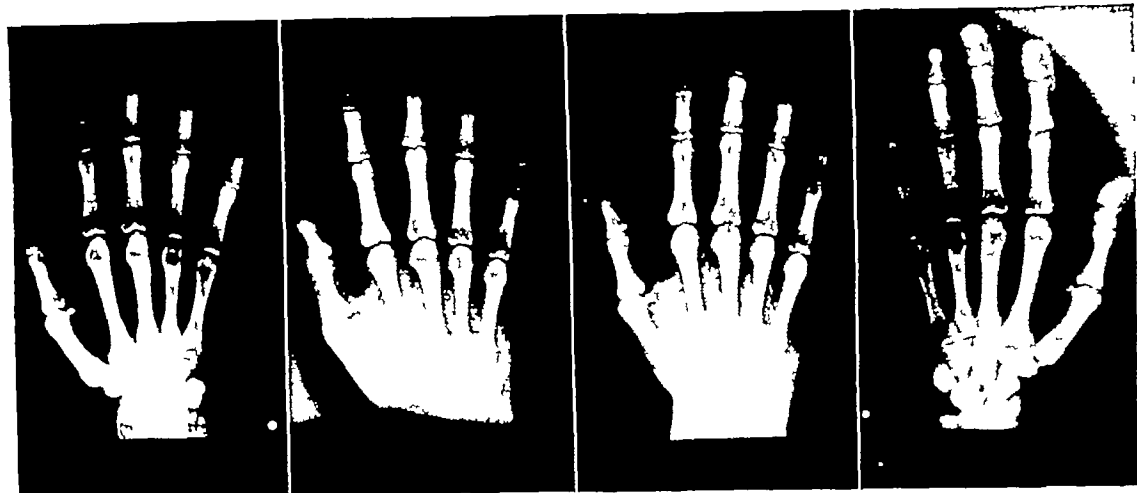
Radiographs of hand made with monochromatic radiation, arranged in order of increasing wave length, left to right molybdenum, copper, cobalt chromium
